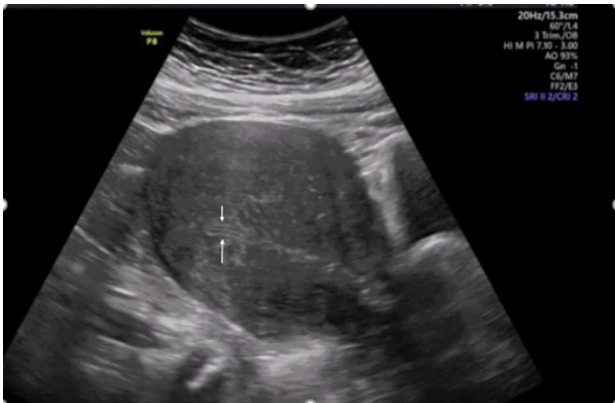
Adenomyosis. Transabdominal ultrasound showing a globular uterus, with the presence of a large myometrial hypertrophy that affects almost the entire uterine body. The proliferative endometrium is seen between the two arrows. The transabdominal route in these cases of great myometrial hypertrophy may offer better image quality and its use should always be considered.
